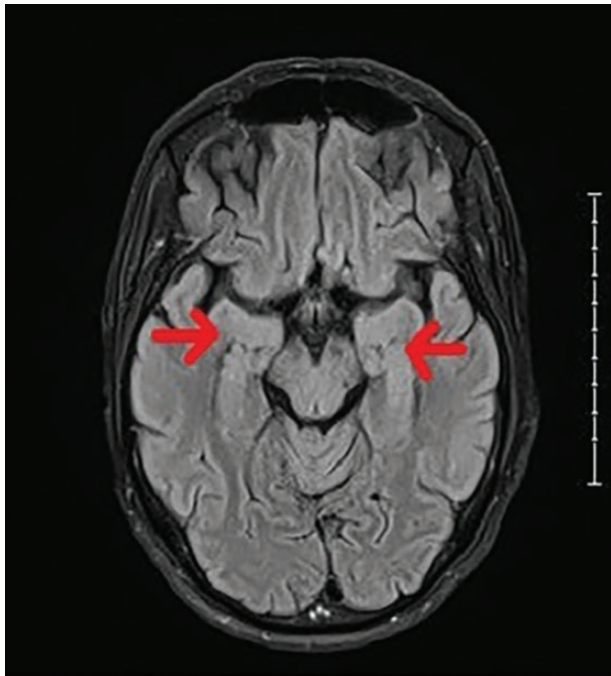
Patient 1 MRI with mild bilateral symmetric areas of T2/FLAIR increased signal within bilateral hippocampi. Abbreviations: MRI, magnetic resonance imaging; T2/FLAIR, T2-weighted fluid attenuated inversion recovery.
